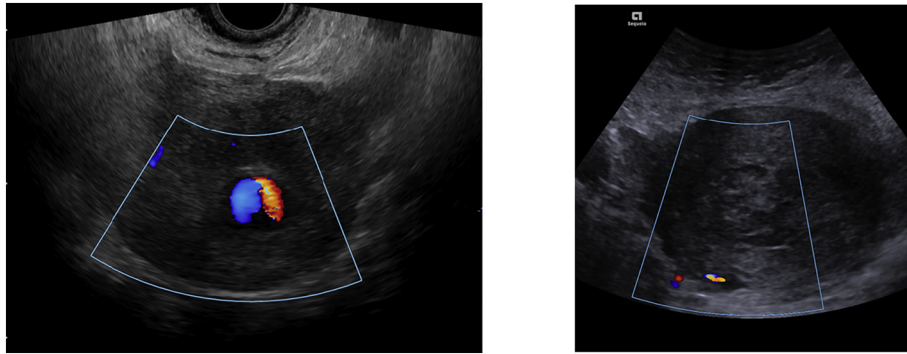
A. Pelvic U/S doppler prior to thrombin injection showing the “to and fro” or “yin yang” sign, with bidirectional flow due to the swirling of blood within the pseudoaneurysm. B. Pseudoaneurysm on U/S doppler after thrombin injection with diminished activity.
